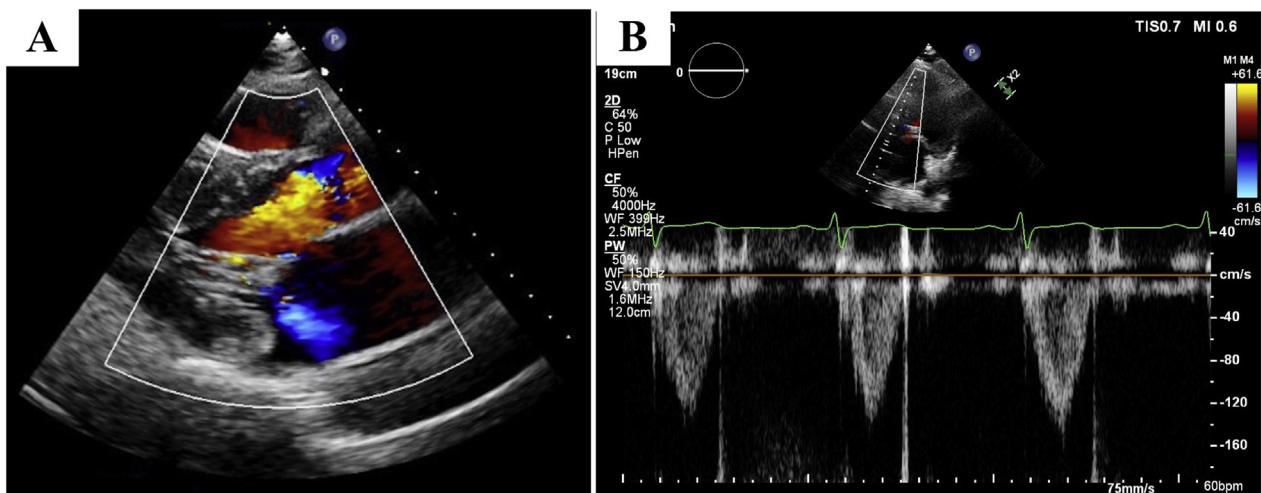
Post-MitraClip TTE. Color Doppler over the MV in the parasternal long-axis view (A) and continuous wave spectral Doppler in the apical four-chamber view (B) showing mild residual MR and no significant LVOT obstruction.
